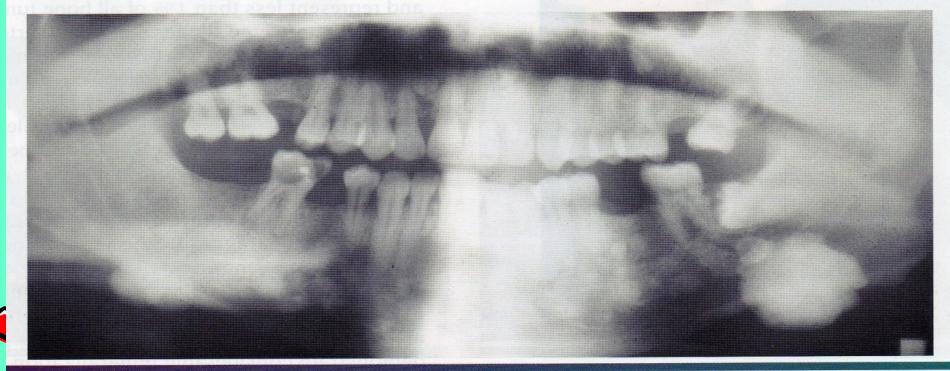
• Gardner syndrome. Panoramic radiograph showing multiple osteomas of the mandible.
